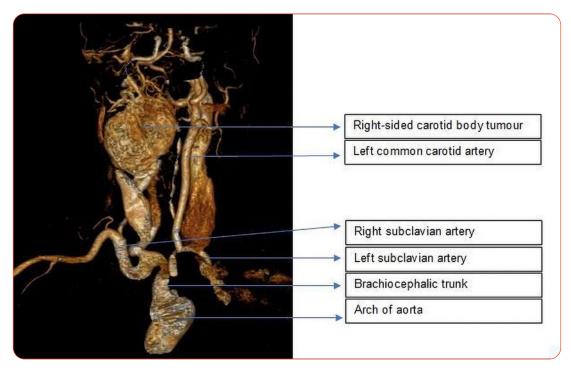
A three-dimensional CT oblique image of the extracranial vessels of the neck, demonstrating the CBT on the right with labelled anatomy.
